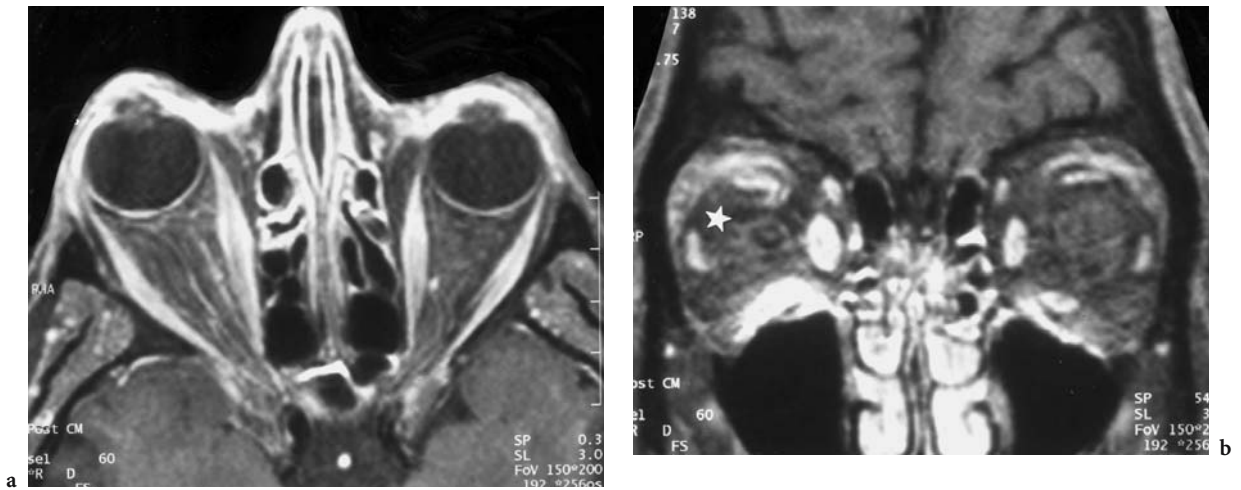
A 75-year-old woman with symptomatology of right-sided retrobulbar neuritis and a history of breast cancer. Diagnosis: idiopathic inflammation of the optic nerve sheath. MRI: a Axial, T1-weighted, contrast-enhanced (FS) view showing enhancement of the right optic nerve sheath. b Coronal view confirming additional infiltration of the paraoptic orbital fat (*white star*) suspected from another axial view (not shown). Differential diagnosis of meningeal metastasis was excluded on follow-up, which showed complete remission of the clinical symptoms after high-dose corticosteroid treatment, confirmed by neuroradiological imaging (not shown)
